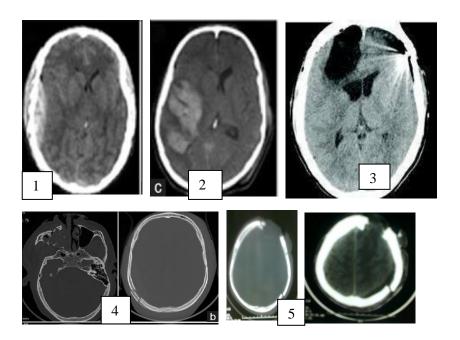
Images from our study on trauma, they are all cross sectional CT images, showing intracranial bleeding (1), brain tear (2), bullet and air in the brain from gunshot (3), facial bone fracture (4) and skull fractures (5).
